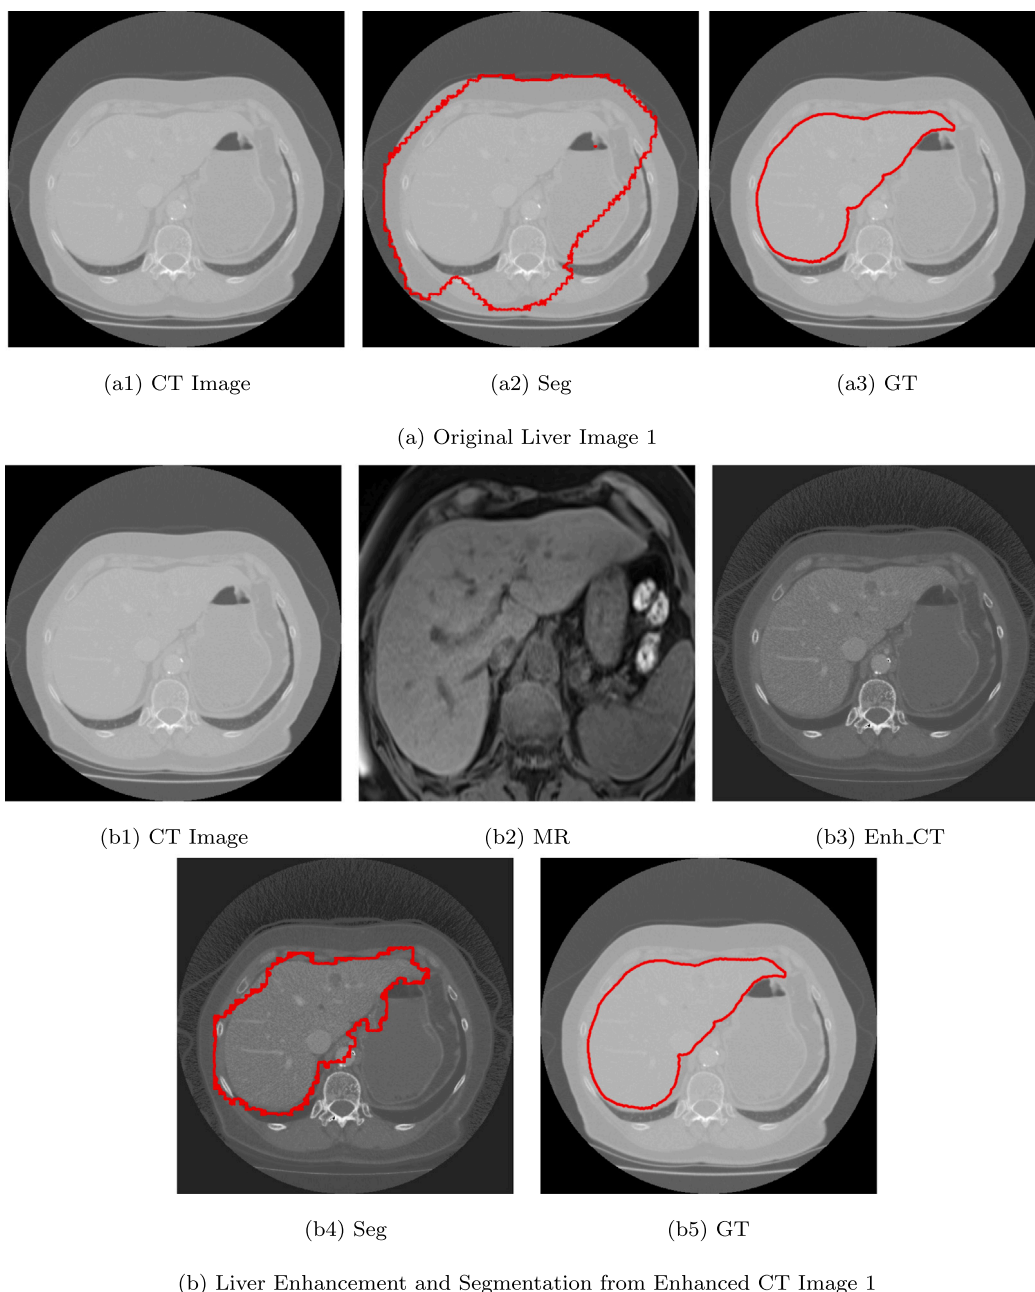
Liver segmentation from original and enhanced CT image 1.
